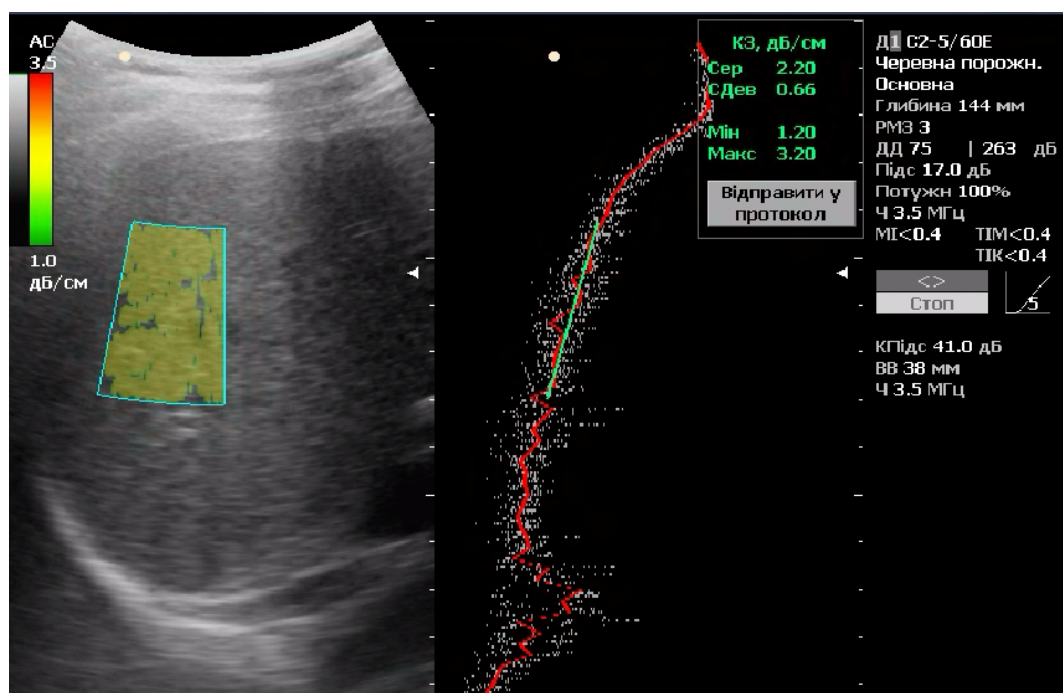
Quantitative ultrasound liver steatometry, stage S1 steatosis
